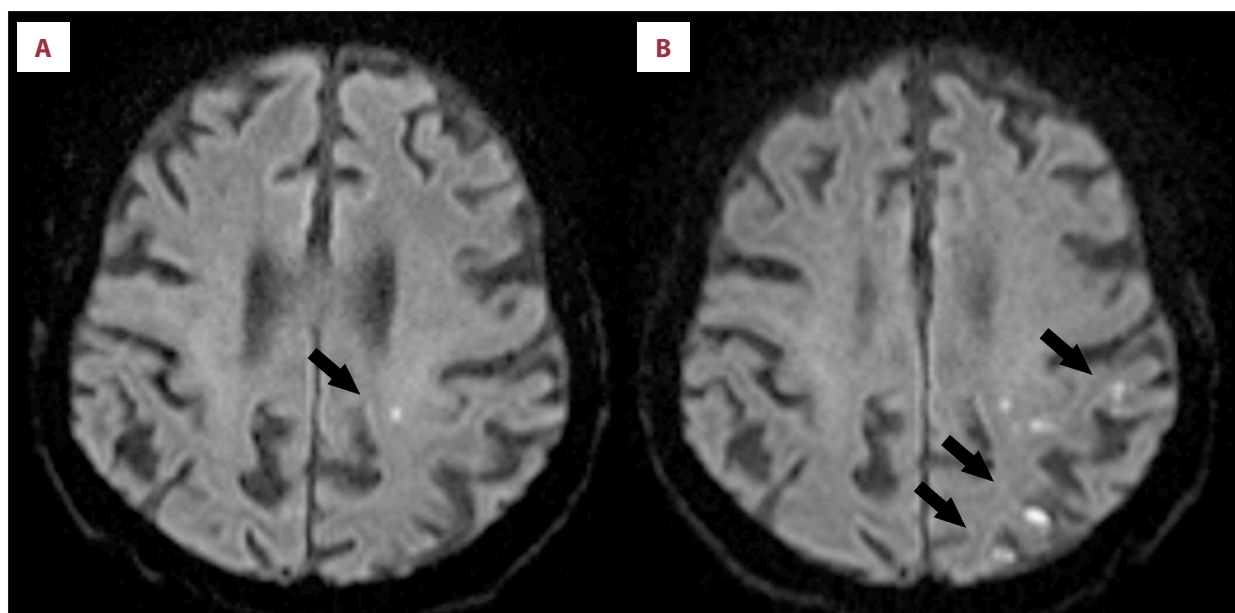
Progression of multifocal ischemia in the left middle cerebral artery territory as seen on day 3 (A) vs day 8 (B) in diffusion-weighted magnetic resonance imaging.
